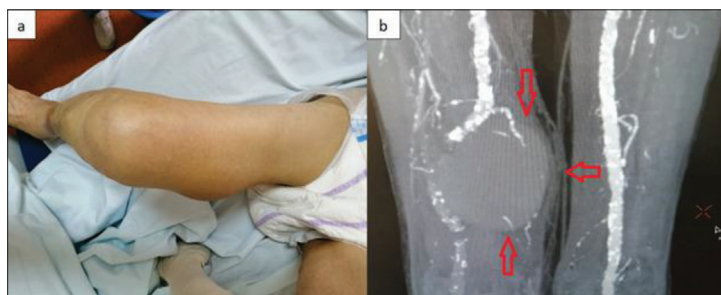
a – Clinical finding of rupture the right superficial femoral artery aneurism rupture; b – computed tomography angiography of the lower limb shows aneurism of superficial femoral artery with compression of neighboring structures (labeled by red arrows)
